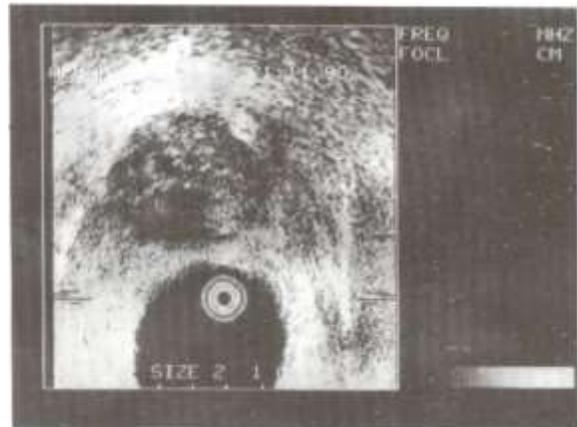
Axial endorectal sonogram showing unconfined prostatic cancer.
